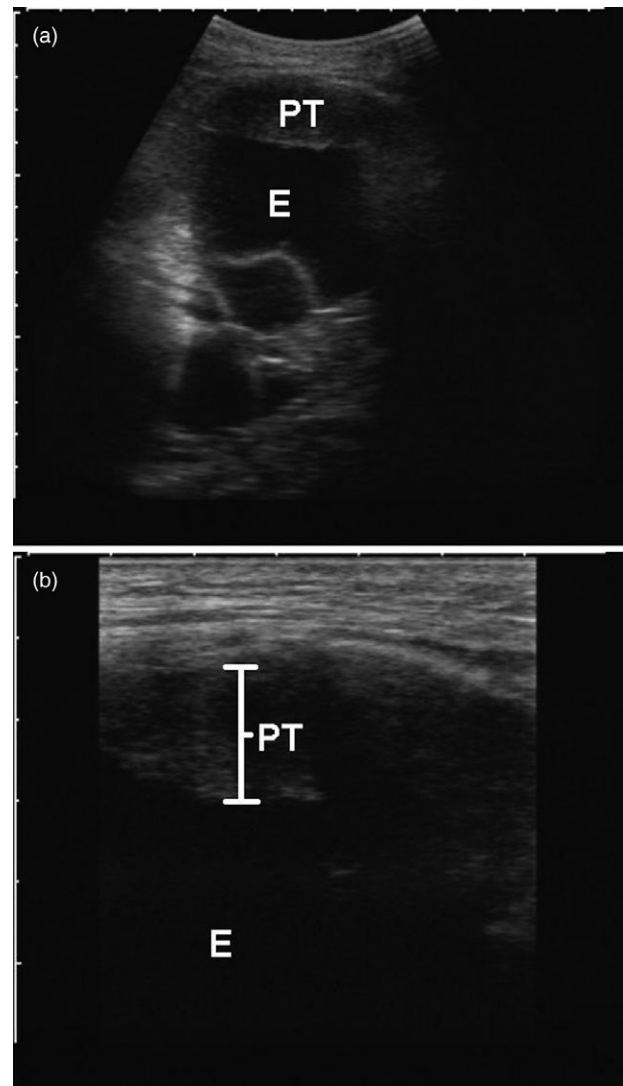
Examples of pleural effusions with relevant pleural abnormalities that may be present on transthoracic ultrasound. (a) This low frequency US image shows diffuse pleural thickening (PT) with an effusion (E). (b) A high frequency image from the same patient (with better resolution but less penetration) showing pleural thickening (PT) with an effusion (E).
